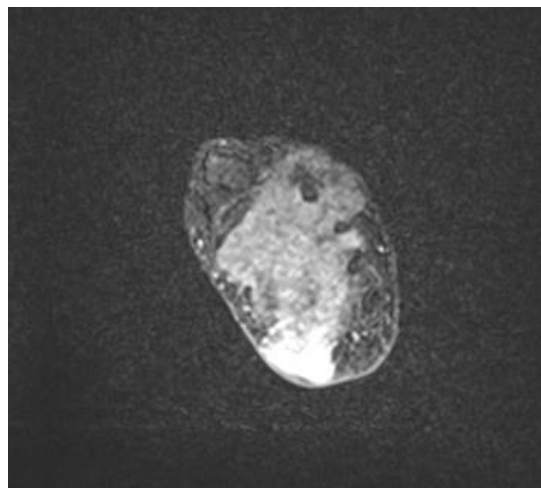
Post-contrast fat-suppressed T1-weighted MRI sequence demonstrating avid and heterogeneous enhancement of the mass following intravenous gadolinium administration (arrows), suggesting high vascularity and active proliferating components
